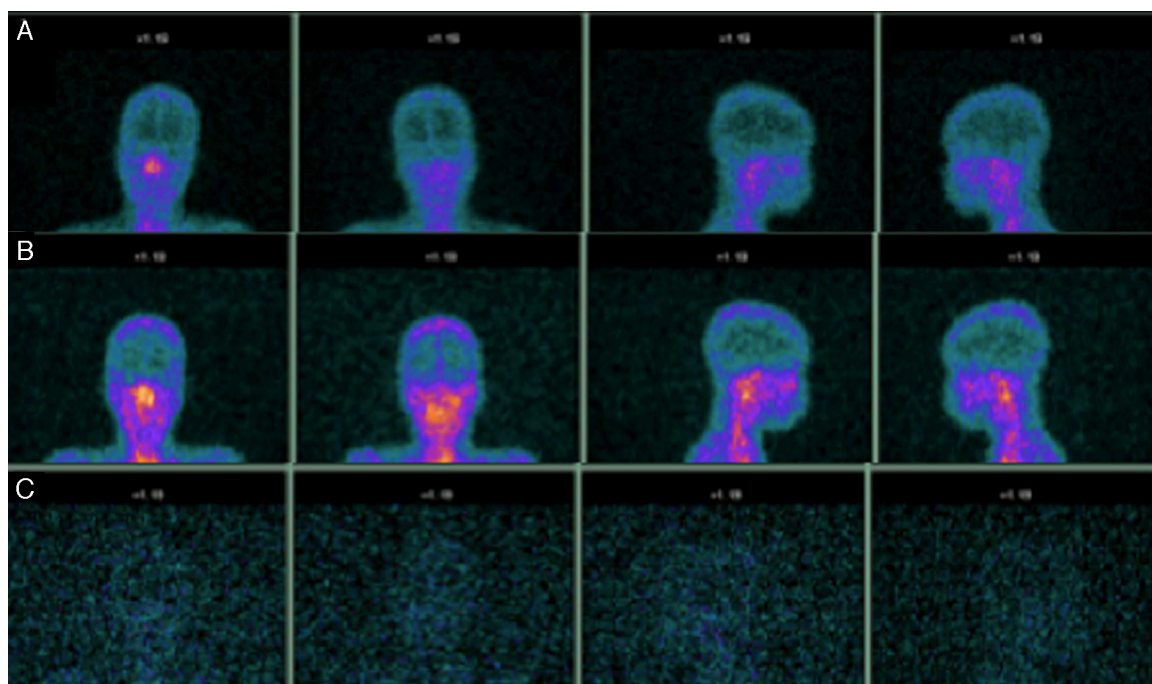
^{99m}Tc -mononuclear leukocyte scintigraphy (A–C). Planar scintigraphs from one, three, and 24 h after labeled mononuclear leukocyte administration indicate no uptake along the mastoid topography over time.
